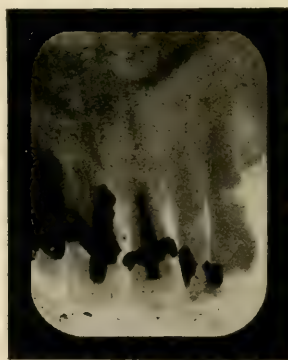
Two central incisors in the same mouth. The posts in the two centrals pass through perforations, one to the labial, one to the lingual. The two radiographs respectively both show and fail to show the posts passing through the perforations.
